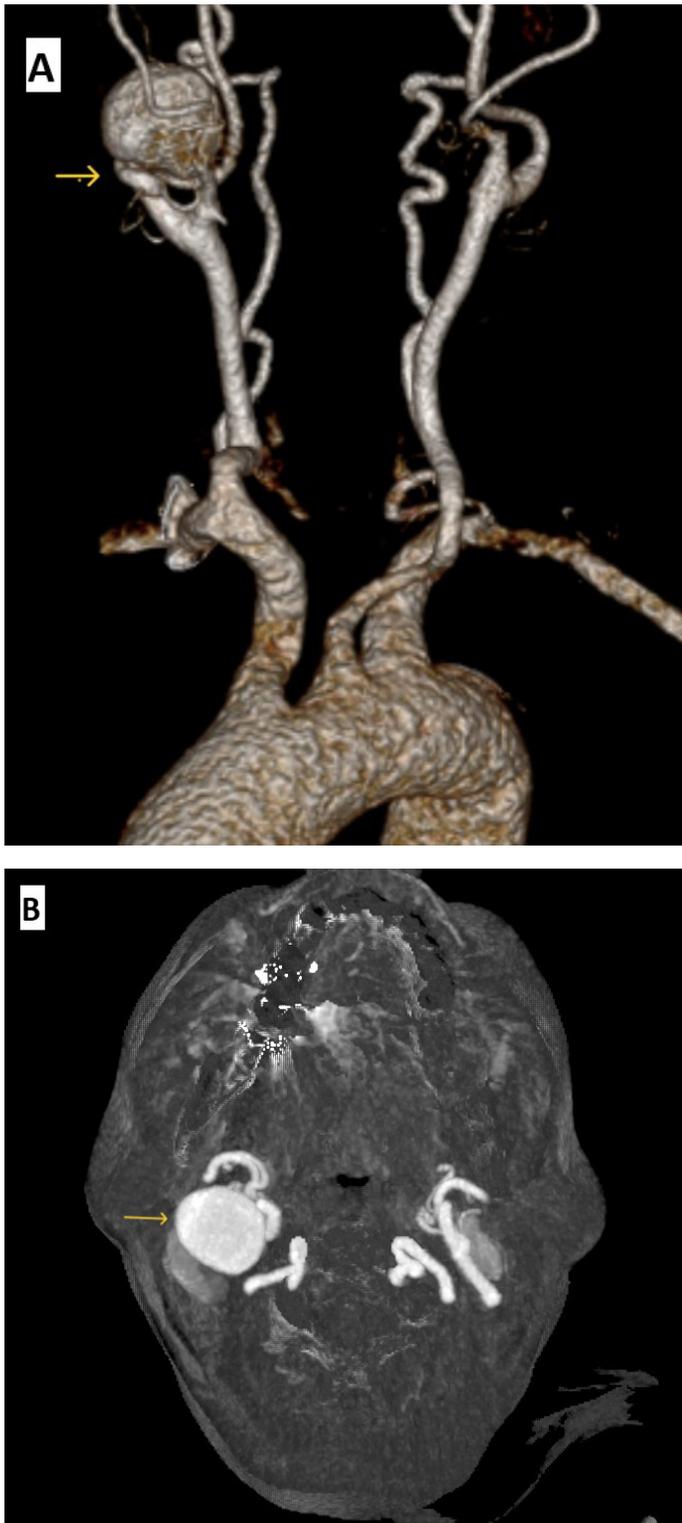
Preoperative imaging of the internal carotid artery aneurysm. A: Computed tomography angiography (CTA) shows the anterior view; B: magnetic resonance angiography (MRA) shows the axial view of the aneurysmal segment
